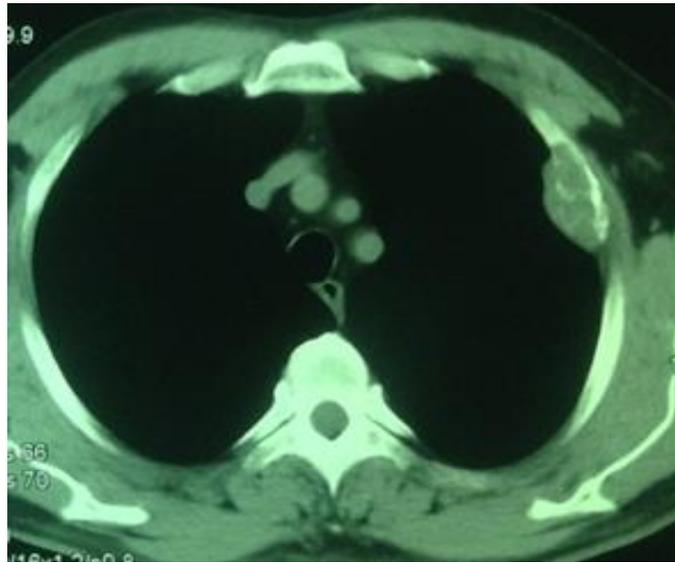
In this view of lung with CT contrast can be seen a lytic lesion in ribs, medial portion of left lung (before Imatinib)
